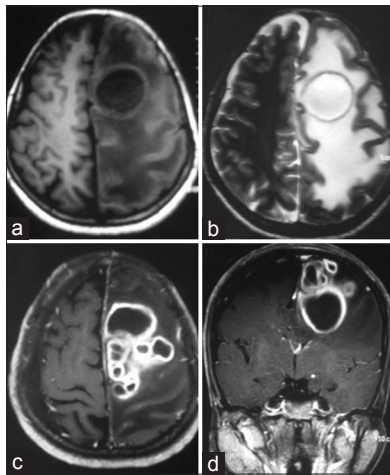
Magnetic resonance imaging of the brain revealed multiloculated lesions in left medial frontal lobe. Largest of these lesions demonstrated central hypointense signals on T1-weighted imaging (T1-WI) with corresponding hyperintense signals on T2-WI (a and b). The peripheral rim revealed isointense signals on T1-WI and hypointense signals on T2-WI (a and b). On administration of gadolinium contrast multiple ring enhancing lesions was noted (c and d)
